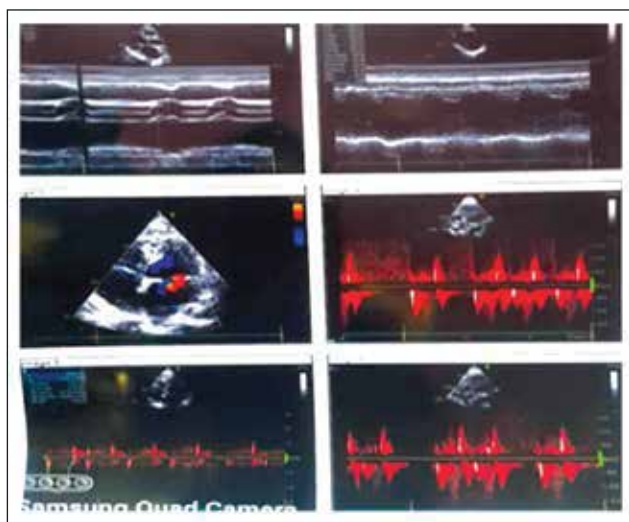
Echocardiographic findings 6 months after radioactive iodine (RAI) ablation showing mild (grade I) mitral regurgitation (MR), pulmonary artery systolic pressure (PASP) 33 mmHg, and left ventricular ejection fraction (LVEF) 61%
